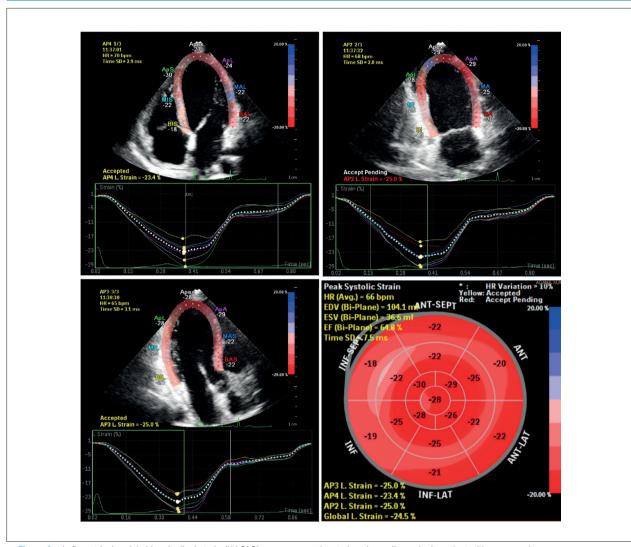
Left ventricular global longitudinal strain (LV-GLS) measurement by strain echocardiography in patient with acromegaly.
